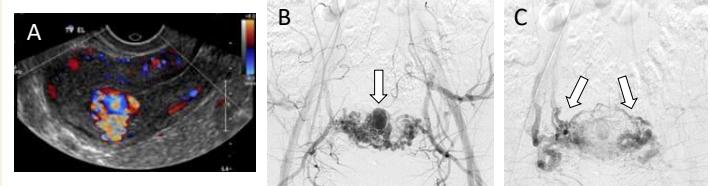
(A) Doppler ultrasound showing turbulent flow through the AVM. (B) Pelvic angiogram showing uterine AVM (arrow) supplied by branches of both uterine arteries. (C) Slightly delayed phase of pelvic angiogram demonstrating rapid venous shunting (arrows) into the uterine venous plexus and internal iliac veins.
